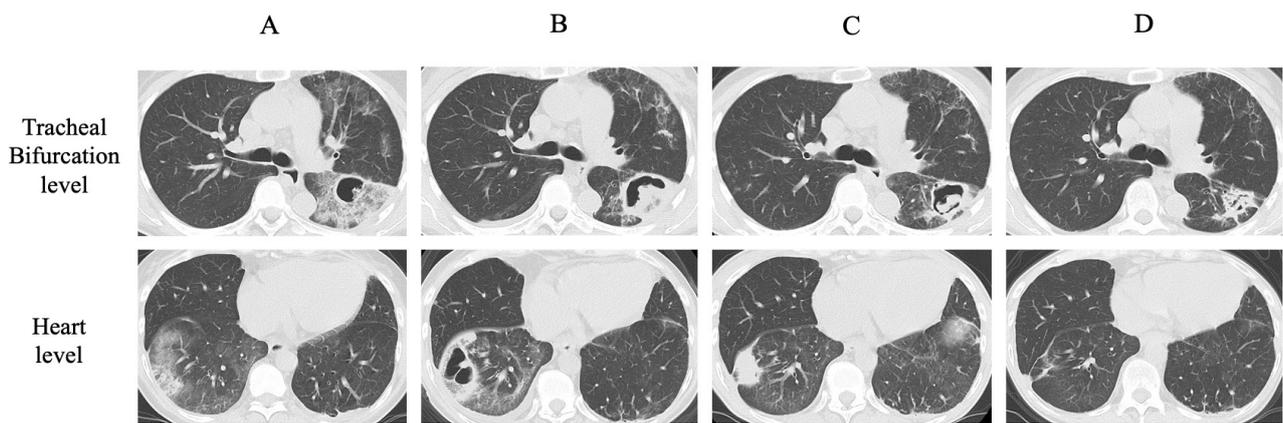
Chest computed tomography at the height of tracheal bifurcation and at the height of heart showed the shadows in both lower lung lobes on the initial admission (A), on the second admission (B), two months later from the initial admission (C), and six months later from the initial admission (D).
